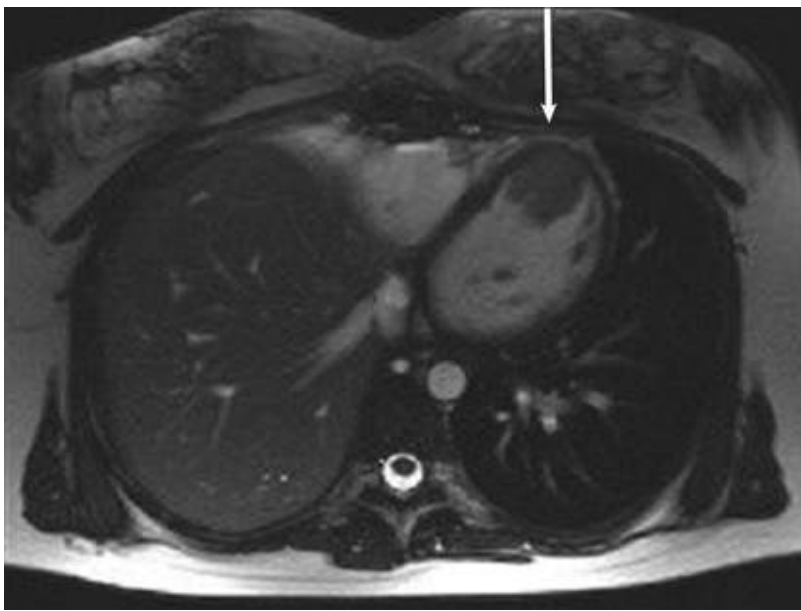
T₁-weighted cardiac MRI of a left ventricular apical tumor of metastatic alveolar cell sarcoma. Note the indistinct nature of the tumor infiltrating the myocardium (*arrow*). This is in contrast to the distinct line that classically separates thrombus from myocardium.
